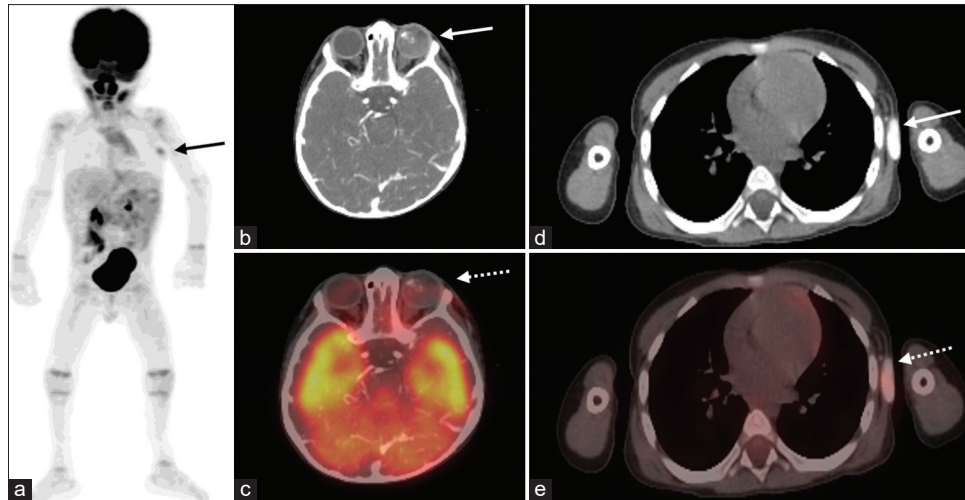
The MIP (a) image shows the calcified left axillary lymph node. The axial CT (b) and axial PET/CT fused (c) images show left eye extra-ocular retinoblastoma with internal calcifications (white solid arrow and white dotted arrow respectively). The axial CT (d) and axial PET/CT fused (e) images highlight the calcified left axillary lymph node (white solid arrow and white dotted arrow respectively)
